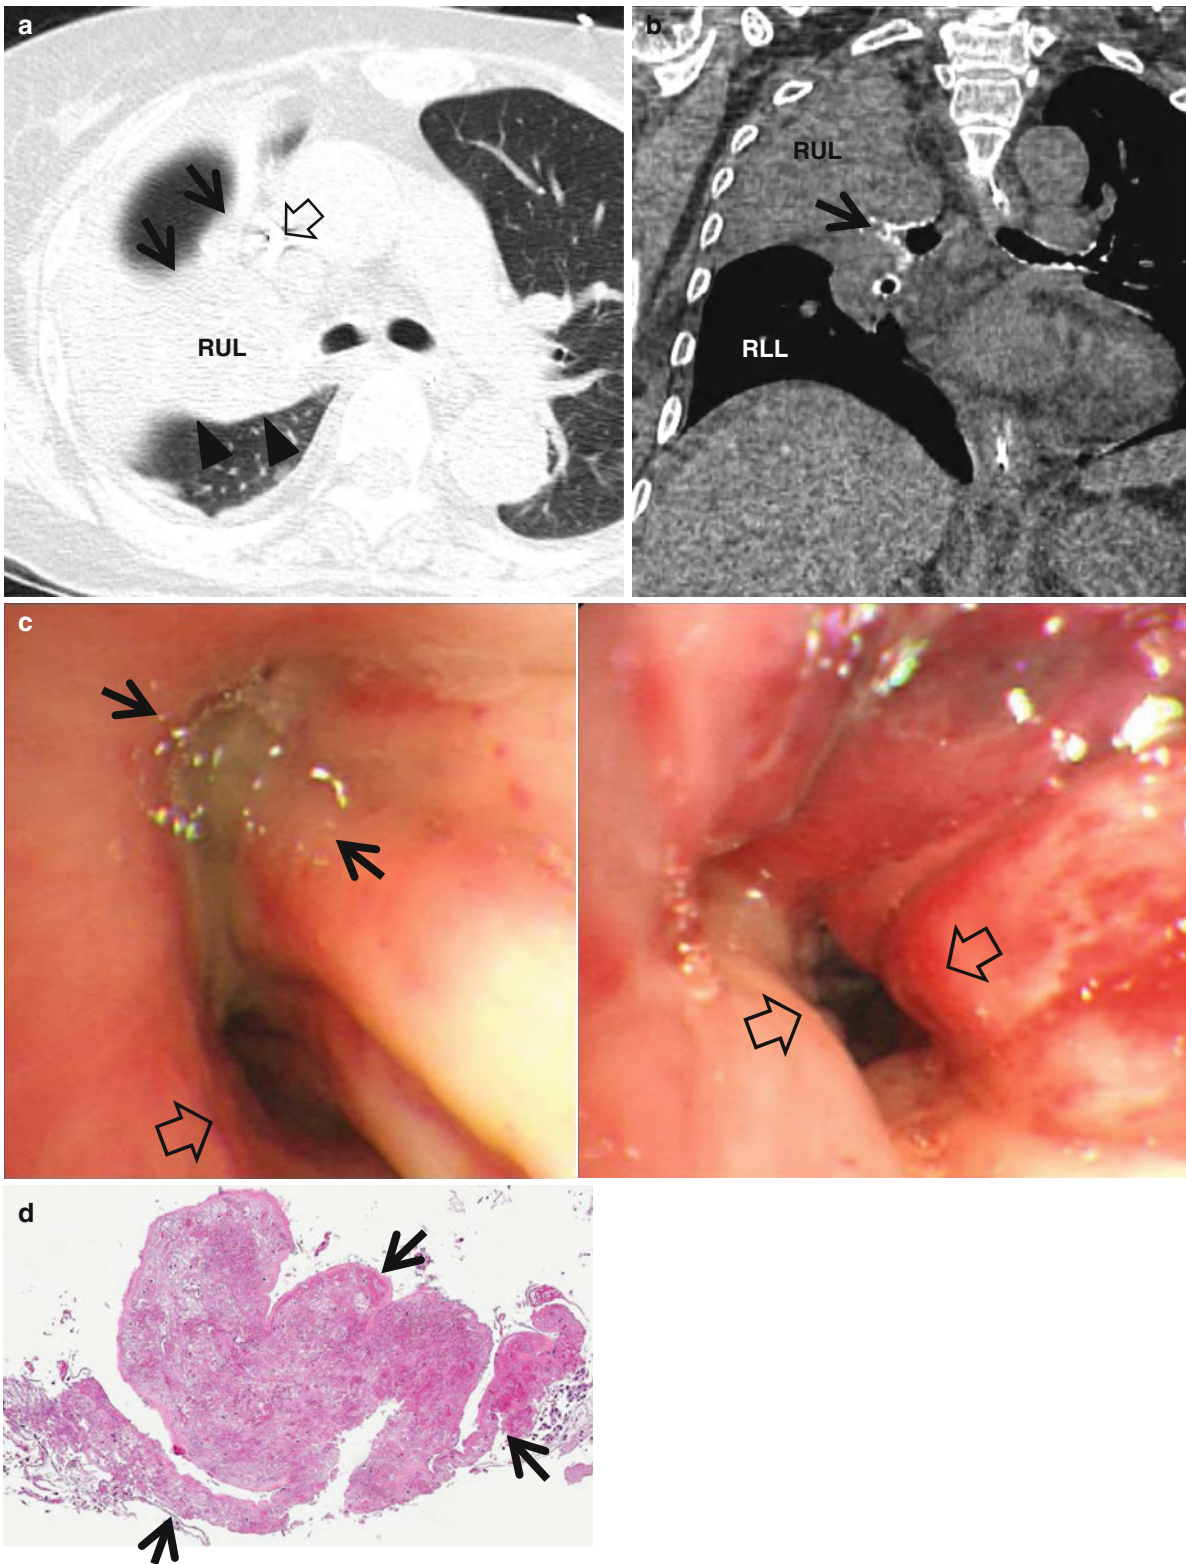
Right upper lobe atelectasis due to bronchial aspergillosis in a 62-year-old woman who has diffuse large B-cell lymphoma. (a) Lung window image of CT scan (2.5-mm section thickness) obtained at level of the main bronchi shows the atelectatic right upper lobe bounded anteriorly by right minor fissure (arrows) and posteriorly by right major fissure (arrowheads). A central venous line (open arrow) is inserted for chemotherapy. RUL right upper lobe. (b) Coronal reformatted image (2.0-mm section thickness) demonstrates the obliterated right upper lobar bronchus (arrow) with intraluminal soft tissue, causing right
